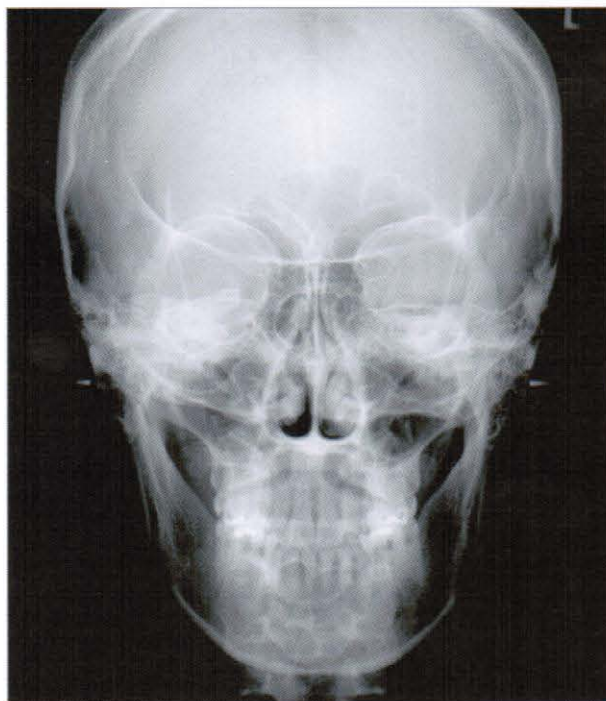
Postero-anterior radiograph at debonding
